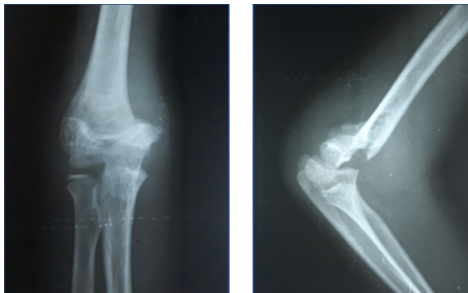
Showing preoperative X-ray of a 9 year old boy with type III supracondylar fracture of right humerus in AP and Lat views planned for open reduction and crossed pinning
